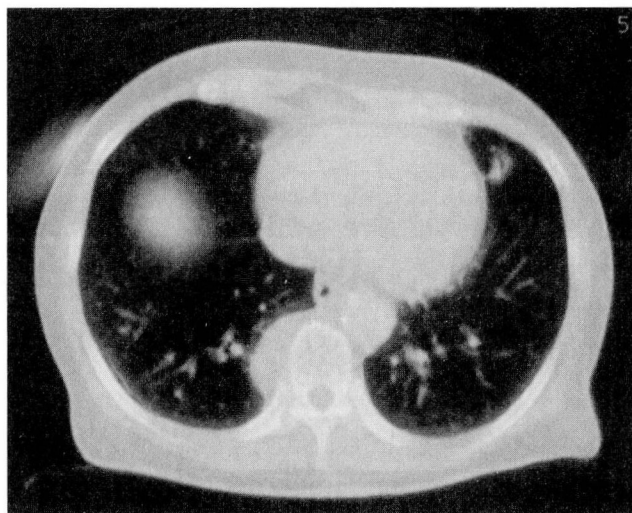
Computed tomographic mediastinal window image confirming the posterior mass lesion (Hounsfield unit value 36).
